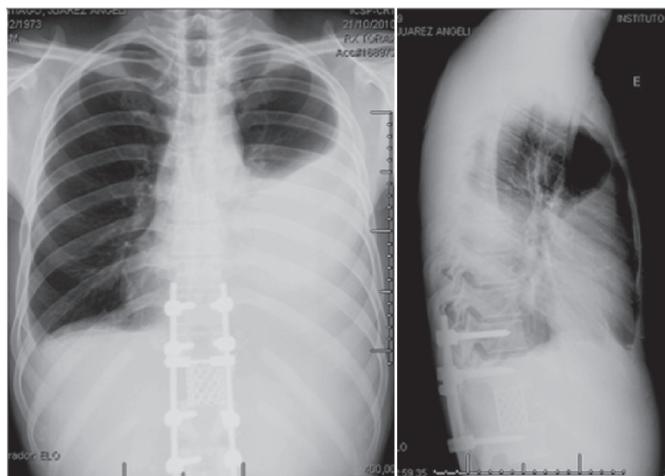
Chest radiograph showing left lung opacity resulting from the chylothorax profile.
